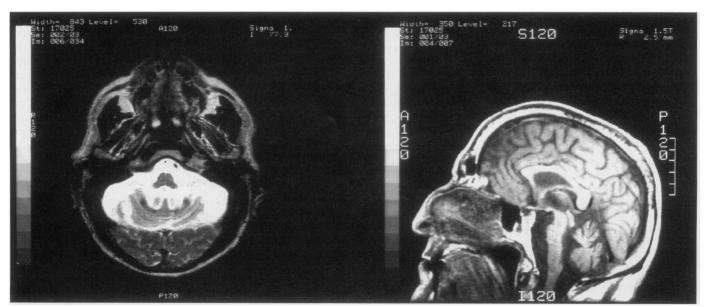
Magnetic resonance image showing olivopontocerebellar atrophy in a patient who had been occupationally exposed to carbon disulfide for over 30 years.
